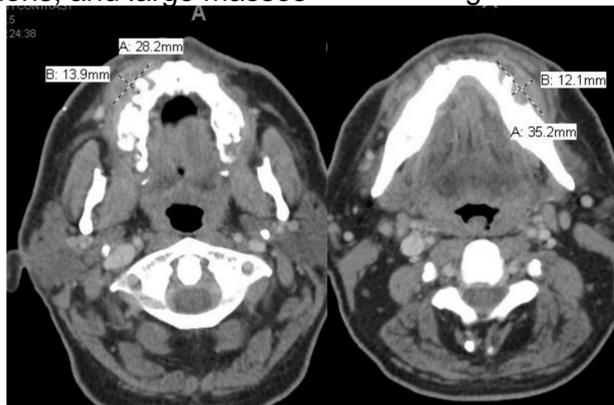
Initial CT-scan showing R maxillary and L mandibular masses.
